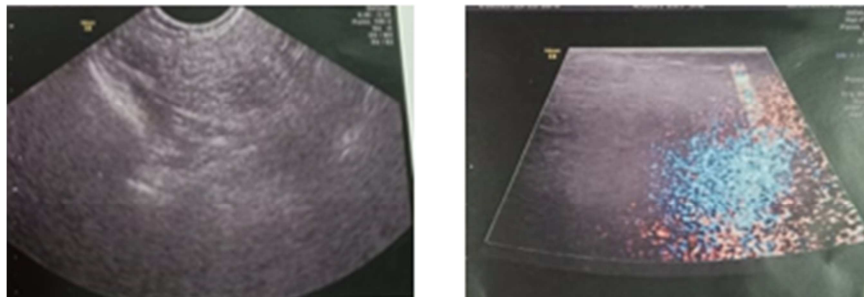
Lipomatous-like formation of 7 cm long axis, circumscribed intrahypodermal, without vascularization on color Doppler.
